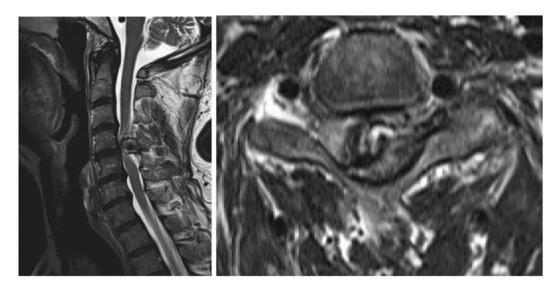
Cervical MRI shows the cervical spinal cord compression due to an unclear tumorous lesion at the C4 level and cervical spinal cord displacement to the right side, starting from the bone to the left facet joint at this level.
